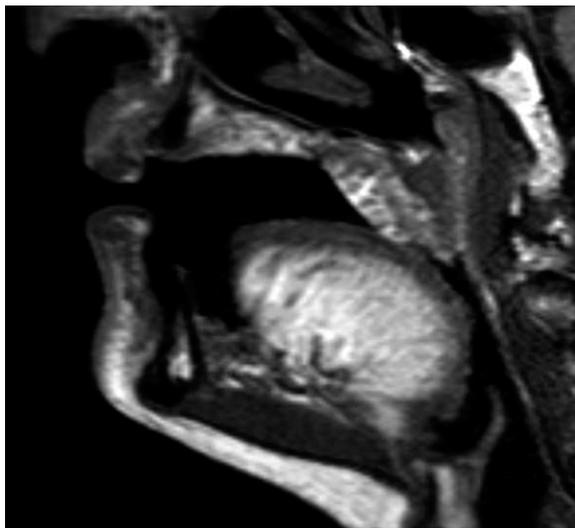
MRI performed in subject 13, who had moderate lingual weakness. Imaging reveals diffuse fatty infiltration of the tongue, lingual muscle atrophy, and peripheral venous drainage of the tongue.
